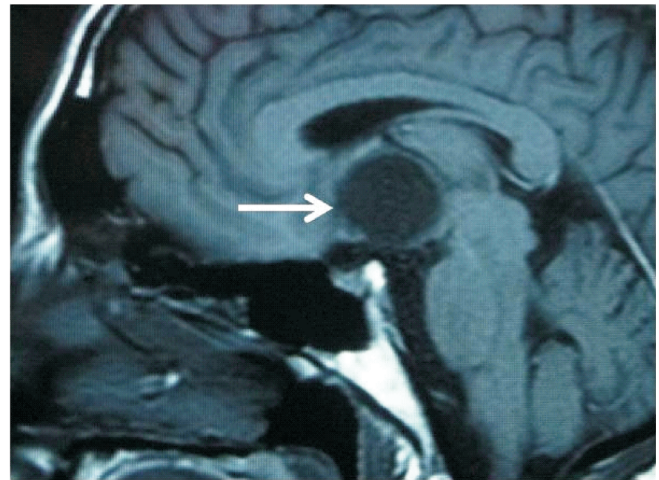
The MRI scan (T1-weighted sagittal cut) of a 44-year-old man with a 3-month history of headache, visual acuity decline, hypothyroidism and sexual impotence. The arrow shows a cystic hypothalamic tumor.
